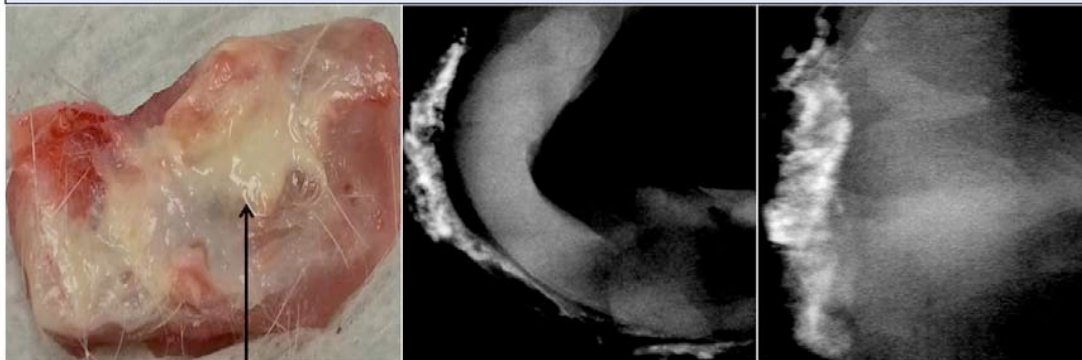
Radiographs at 8 weeks post op.
